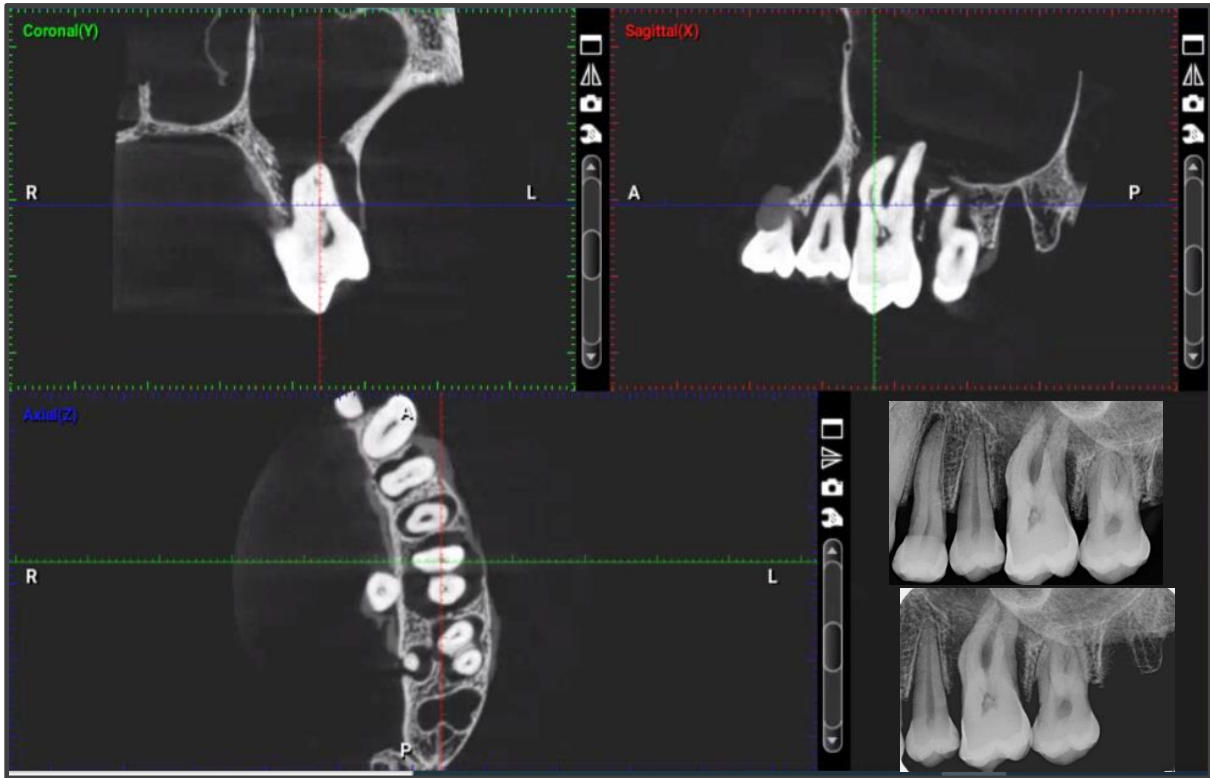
Tooth Z: Imaging provided to operator: CBCT dataset image and inset: parallaxIOPA's: parallel image (upper), 30° to the parallel image (lower). IOPA: Intraoral periapical CBCT: Cone beam computed tomography.
